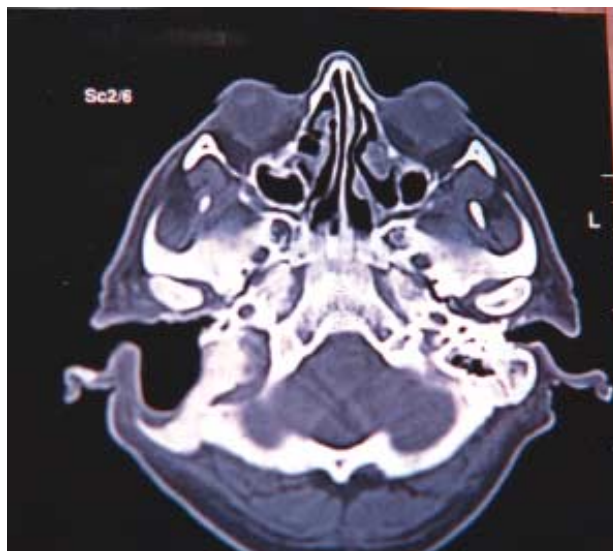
A computed tomographic scan of the right mastoid cavity during the third postoperative month.
